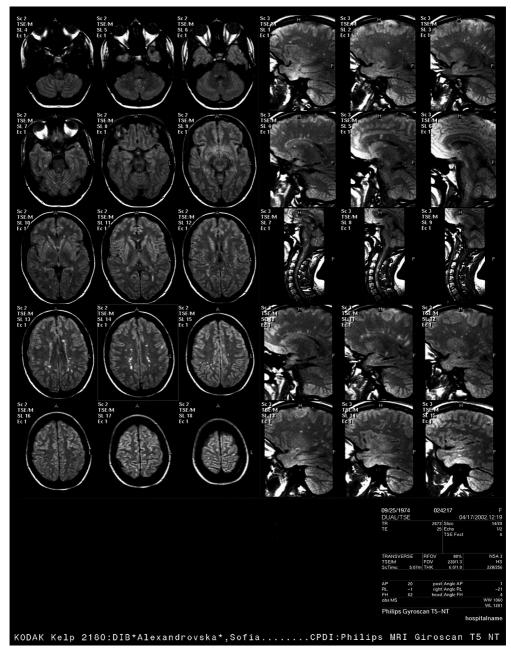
MRI in a patient with RRMS before Glatiramer acetate treatment
